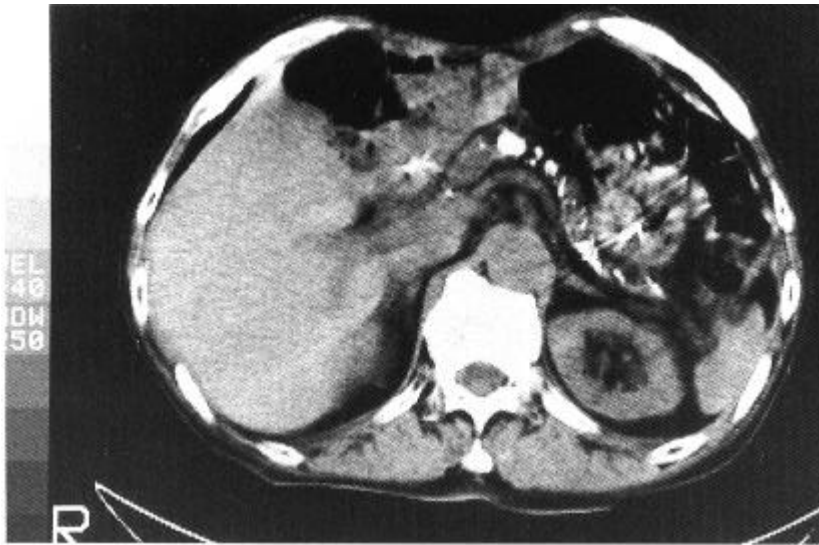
PET image using ^{11}C -Met. of a 70-year-old male with chronic pancreatitis (Case 7 in Table 2). (A) X-CT: Massive calcification in the pancreas can be recognized. (B) PET: PET image of the left is more cranial than the right, and PET image of the upper line is also more cranial than the lower line. The pancreas can not be visualized.
